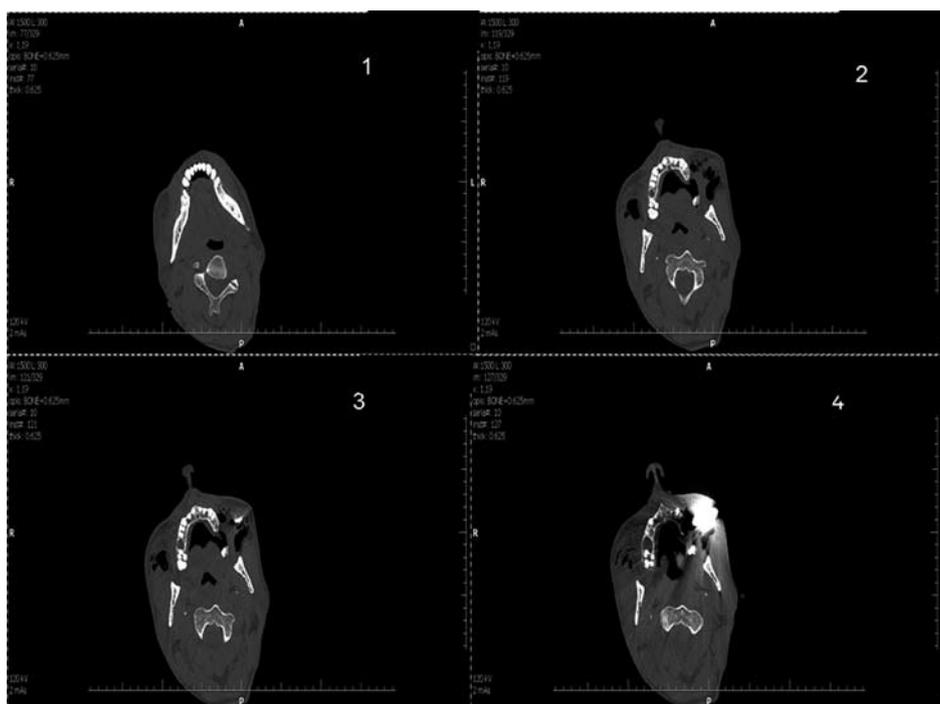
CT images of the skull
